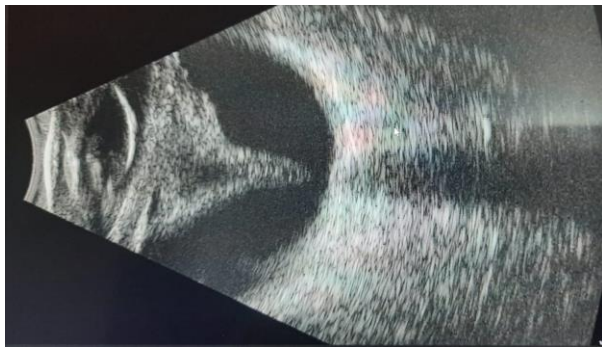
Ultrasound-B indicating funnel shaped retinal detachment
